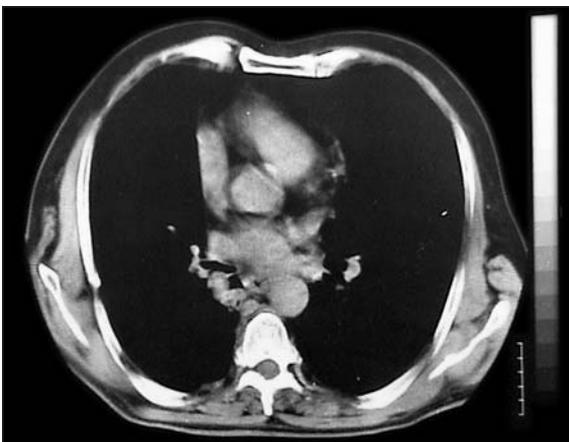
Computed tomographic scan demonstrates a mass occupying right lower lobe bronchus.
